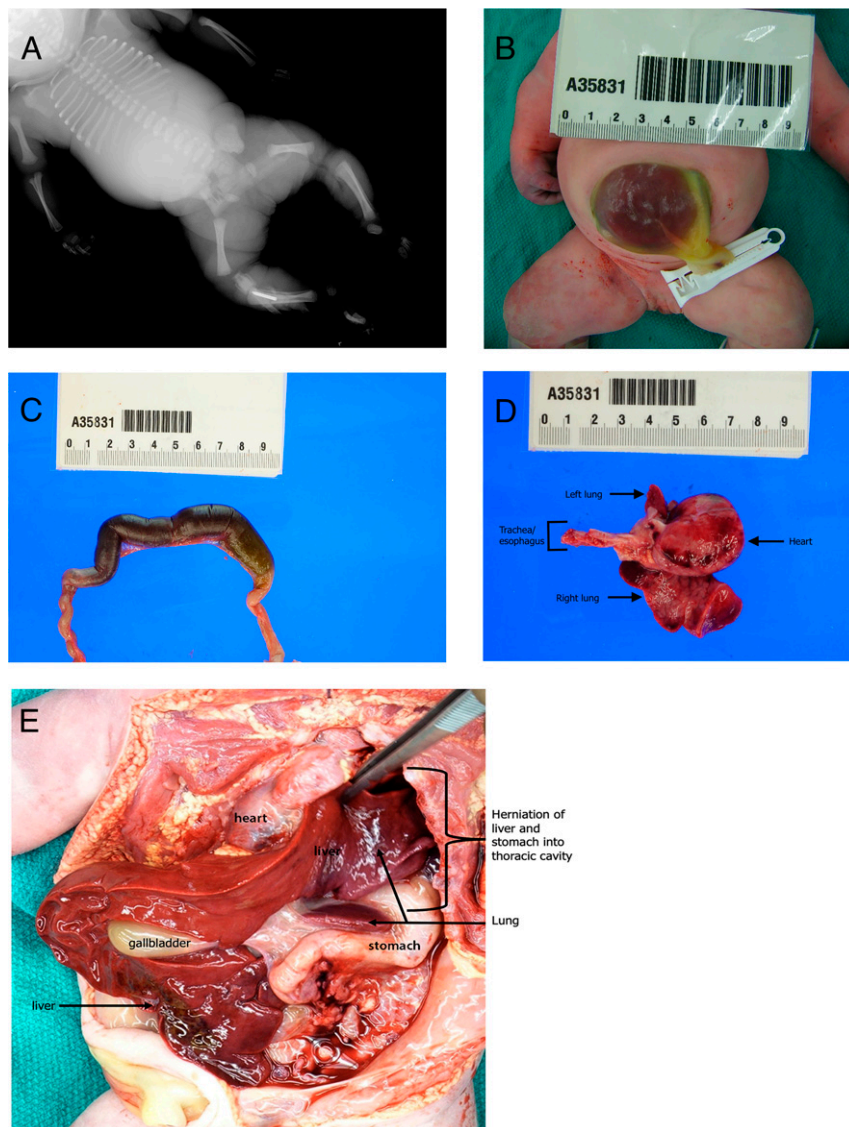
Gross autopsy photographs. A. Skeletal radiograph demonstrating rhizomelic limb shortening. B. Omphalocele. C. Intestinal malrotation containing 10 cm dilated loop of bowel. D. Lung hypoplasia. E. Congenital diaphragmatic hernia containing portion of stomach and liver.
